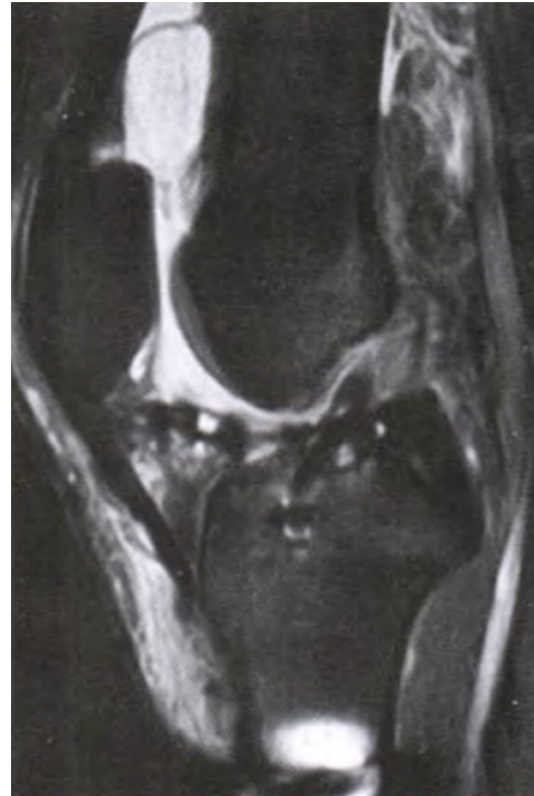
Sagittal MRI showed uniform and continuous anterior cruciate ligament signal, satisfactory bone marrow tract and repair site.
